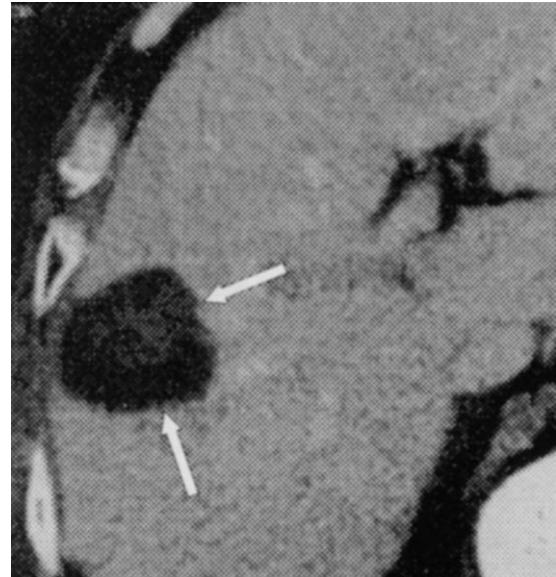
Computed tomographic scan after radiofrequency thermoablation. Arrows indicate areas of necrosis.
